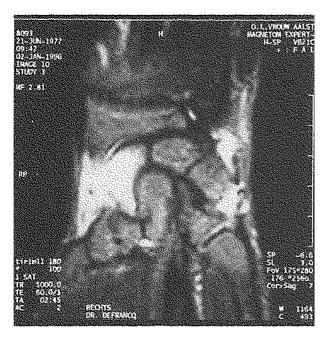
MRI - T_1 (see text).
